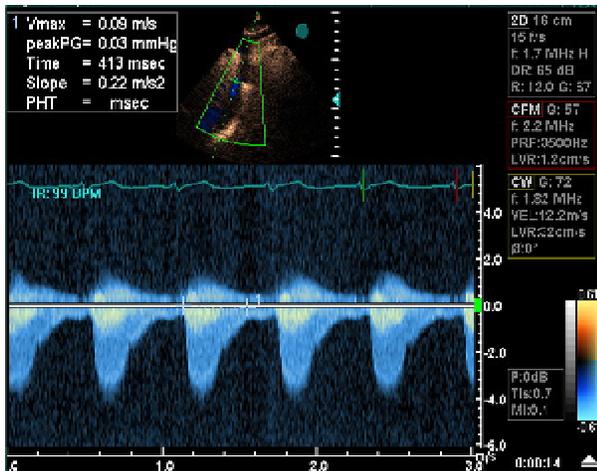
Peak systolic pressure gradient (PPG), mean systolic pressure gradient, and velocity time integral (VTI) in the descending thoracic aorta by CW Doppler study
